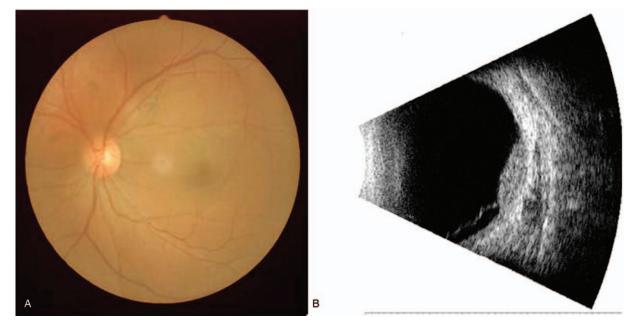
Example of patients with eye metastasis seen on fundus camera and eye B ultrasonic.
